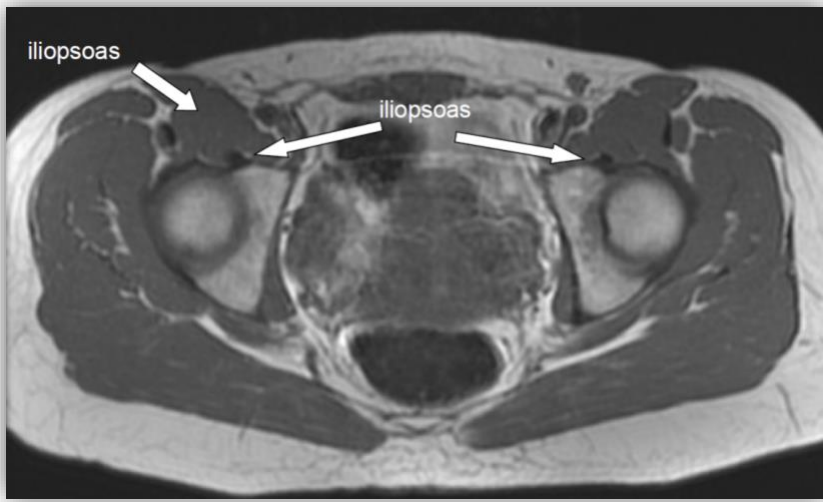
T1-weighted MR image of the pelvis demonstrates the iliopsoas tendons and muscle bellies at the level of the acetabulum.
